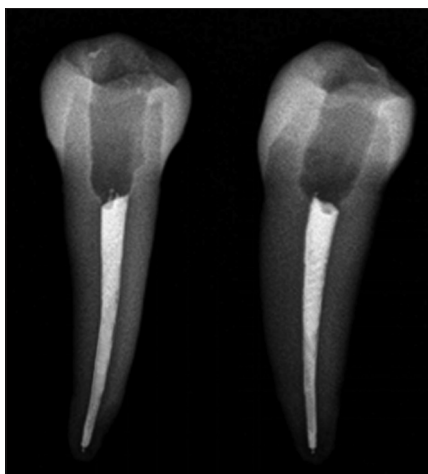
Radiographic examination of teeth after filling to ensure the filling quality
